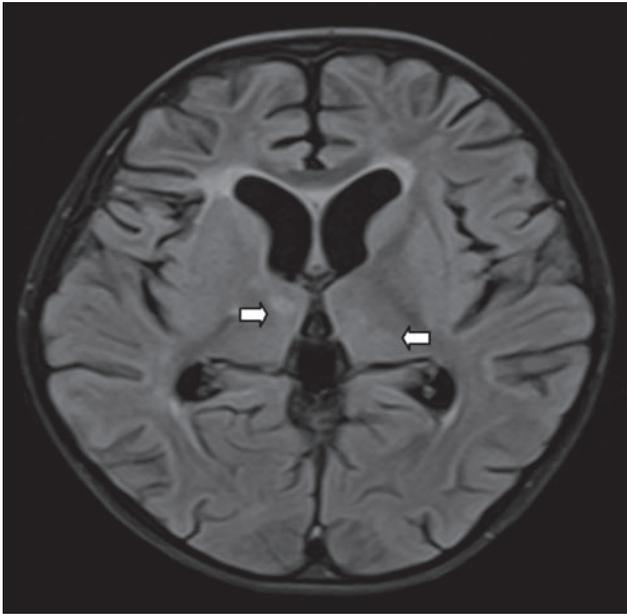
High-intensity signal in bilateral thalami in fluid-attenuated inversion recovery (FLAIR) sequences.
